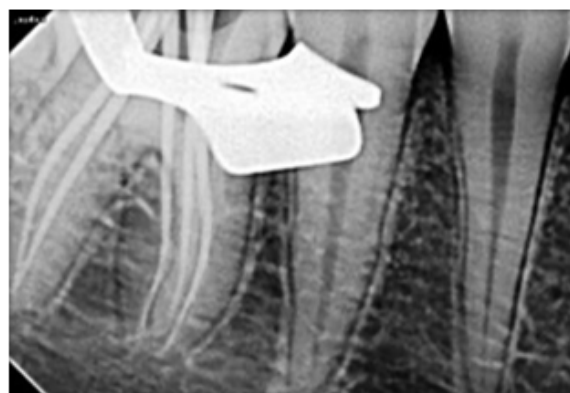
Master cone fit radiograph showing middle mesial canal.
